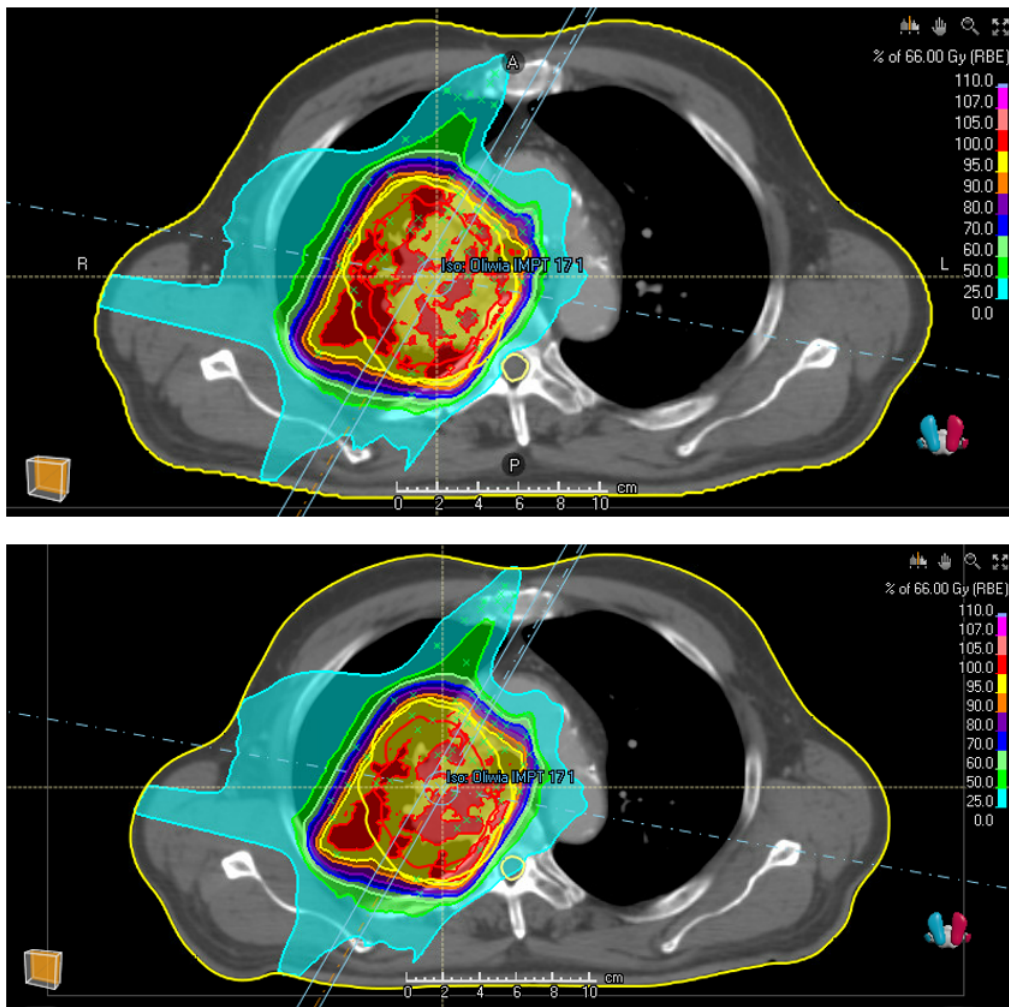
Dose distribution in a single CT slice for patient 17 using the $IMPT_{4.5\%}$ plan. The upper image shows the initial (CT 1) calculation and the image below shows dose distribution recalculated on the control CT (CT 2). Dose to spinal cord (yellow circle) changes significantly from CT 1 to CT 2.
